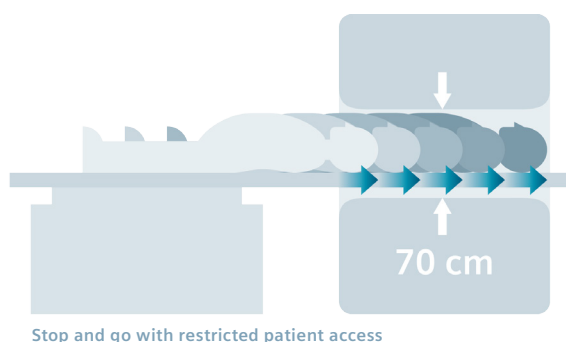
On the left side, planning and scanning in sequential bed positions requires the PET and CT acquisition to expose an area beyond what is needed. With precise CT-like organ-based planning and scanning as shown on the right side, FlowMotion targets only the desired range.
